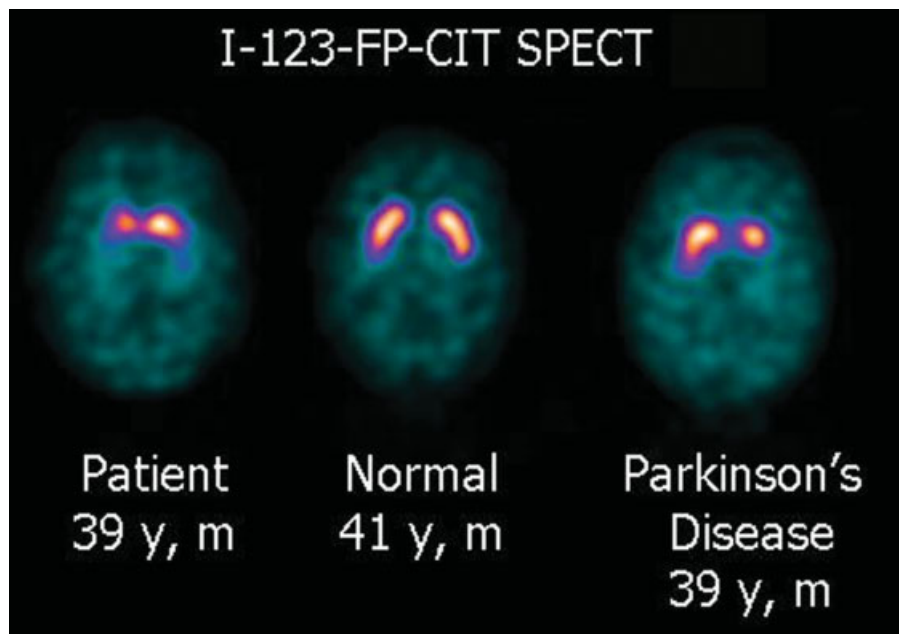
[^{123}I]-N- ω -fluoropropyl-2 β -carbomethoxy-3 β -(4-iodophenyl) nortropine single photon emission computerized tomography (^{123}I -FP-CIT SPECT) of the patient, an age-matched nonaffected control, and an age-matched patient with idiopathic Parkinson's disease. y, years of age; m, male.
